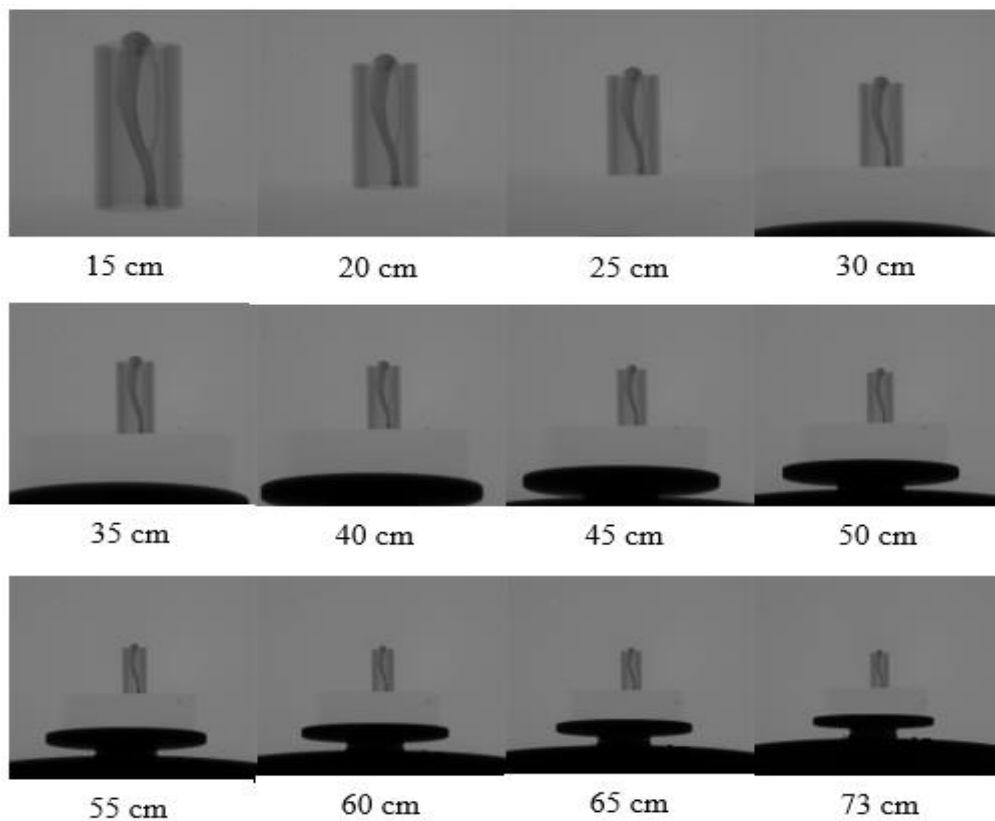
Typical radiographs that were acquired with the FSD range of 15 cm -73 cm, X-ray current of 100 μ A, X-ray tube voltage of 100 kV and X-ray exposure time of 1 sec.
